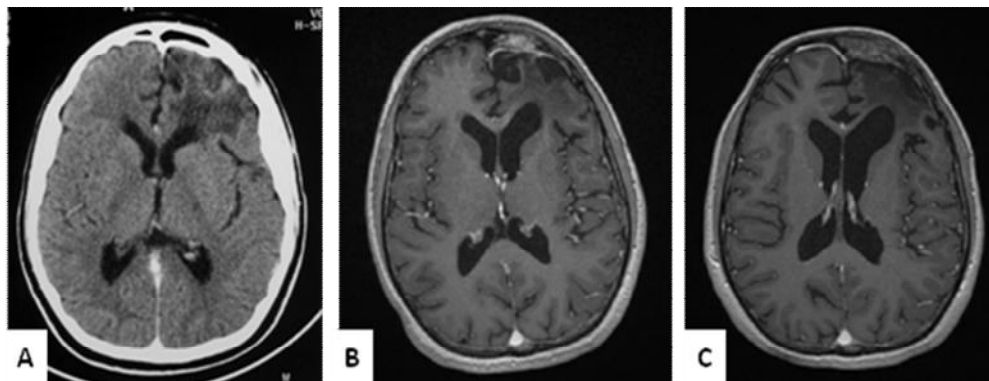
A, cranial axial CT scan with contrast enhancement on the first postoperative month shows a total gross resection of the HPR. B, post-enhanced axial T1-WI revealing a local recurrence of the tumor 3 months after radiotherapy. C, after an additional radiation dose of 10 Gy The recurrence remained unchanged on the 1-year follow-up post-enhanced axial T1-WI
